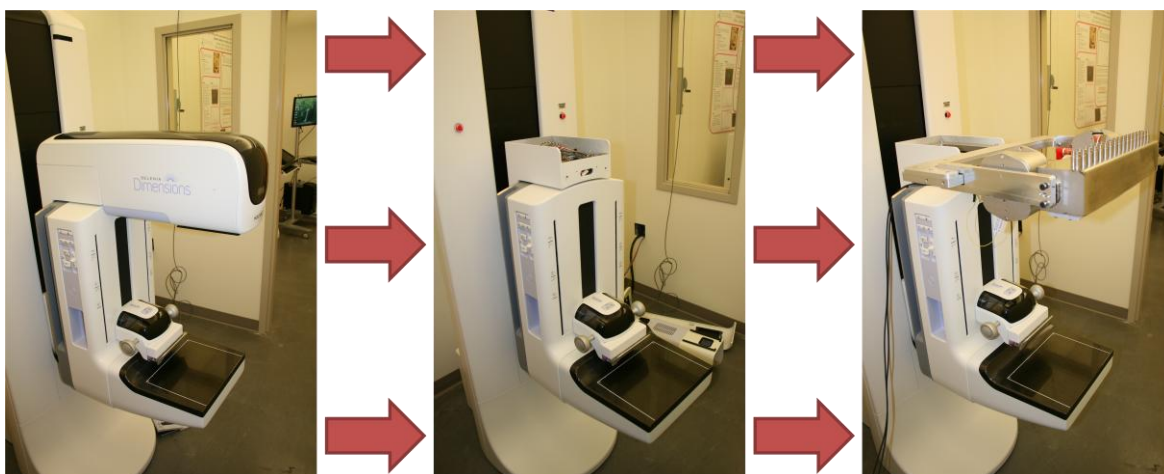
Pictorial time lapse of the Selenia Dimensions gantry (Left), after X-ray tube removal (Center), and after CNT source array integration (Right).
